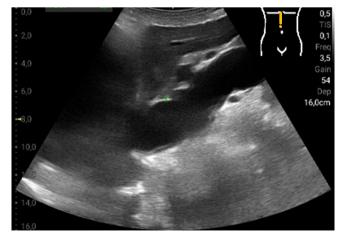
Sonographic image of a vena cava dilated to 27 mm obtained using the Youkey Q7. The patient's diuretic therapy was intensified
